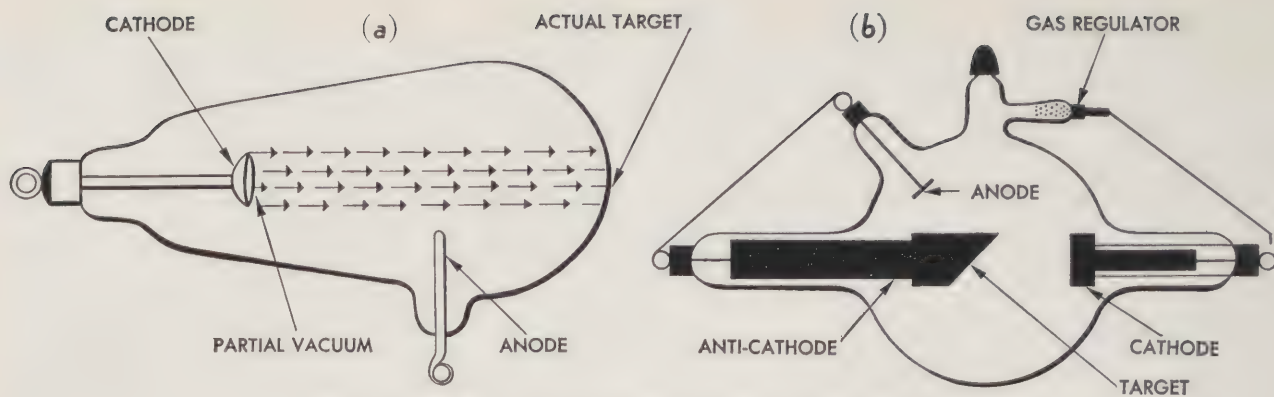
X-ray tubes: (a) Roentgen's tube, (b) Gas tube.
